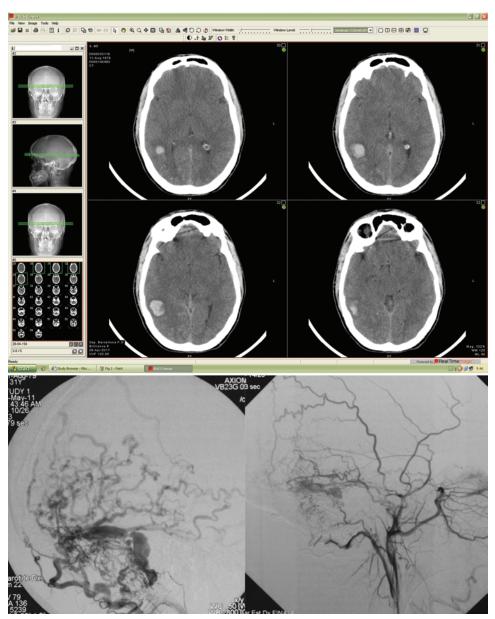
Upper: Brain CT scans obtained in a 27-year-old patient with spontaneous lobar ICH. Telemedicine screenshot reproduces the CT console of the peripheral hospital with visualization of the scouts, multiple slices of the examination, and tools for image management. In general, hematoma without evidence of mass effect was managed at the peripheral hospital, unless one suspected vascular malformations, tumors, or sinus thrombosis, requiring urgent management. In such cases, clinical data collection is fundamental to avoid disastrous delay of diagnosis and treatment. Lower: Angiograms showing evidence of a dural arteriovenous fistula (*left*), which was promptly managed with embolization (*right*).
